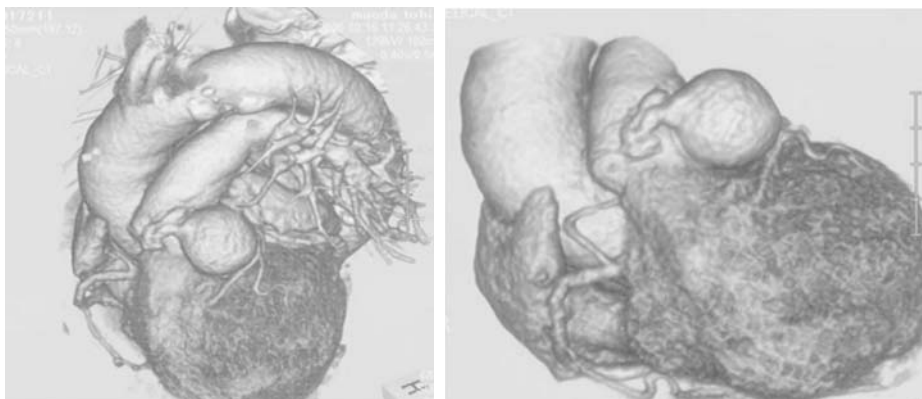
CT image showing a 3-cm-diameter saccular coronary artery aneurysm close to the pulmonary artery.
